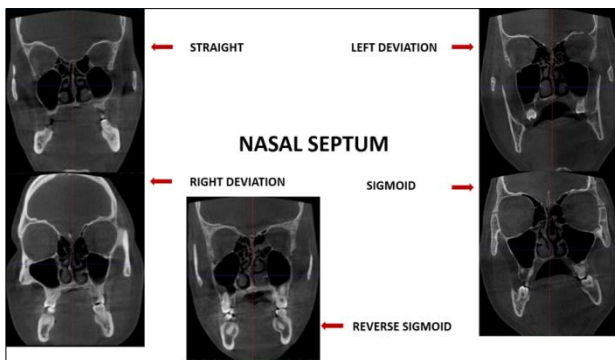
Various patterns of nasal septum as seen in CBCT images
